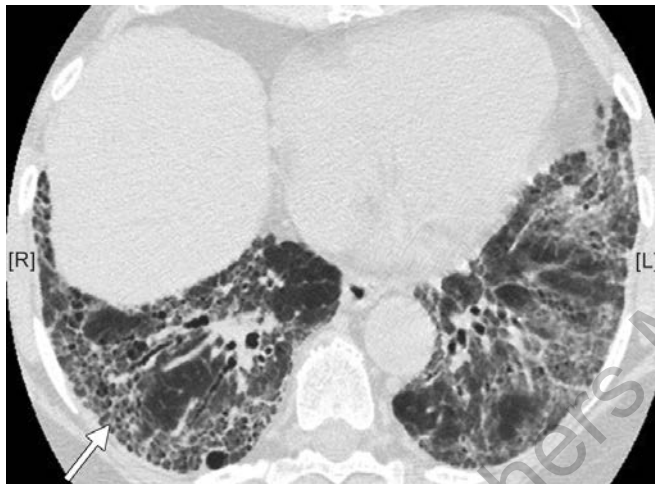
HRCT showing cuts through the lower lobes showing reticular changes including honeycombing, traction bronchiectasis and architectural distortion
